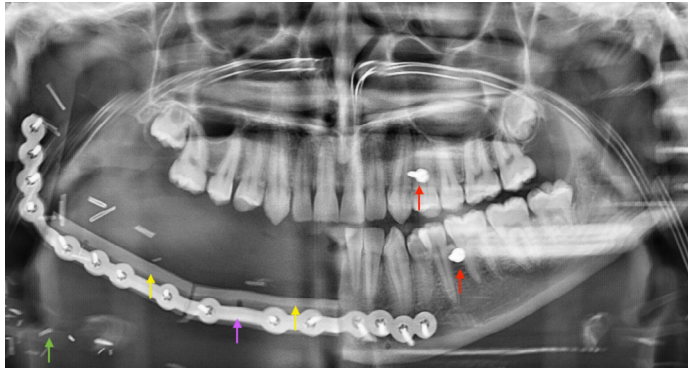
Postoperative orthopantomogram showing fibula flap (yellow arrows) with associated metal ware (purple arrow) and soft tissue vessel clips (green arrow). Left maxillary and mandibular intermaxillary fixation screws (red arrows) in situ for dental approximation. There are plans for dental implant placement and prosthetic rehabilitation in the near future
